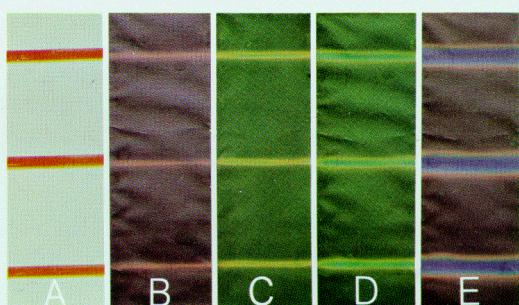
A-B-C-D-E. Representation of the colour display of a C.L.C. plate with <<lower thermal level>> at 33°C (ELC Thermo System Bayer, plate 33). The plate is applied to a spiral shaped plastic straw placed in a grooved container made of thermal insulating material. The temperature of the liquid flowing through the straw progressively increases. A) Straw *in situ*: visualized by coloured liquid. B) <<Lower thermal level>>; liquid flowing at 33°C. The straw image appears red coloured on the plate. C), D) Sequence of the plate chromatic variations with T fluctuations; C) 34°C: green colour; D) 34.5°C; the green colour persists together with the appearance of small, orange coloured, chromatic halo (lateral thermal diffusion). E) <<Upper thermal level>>; liquid flowing at 35°C: blue colour. Slightly larger chromatic halo with additional colours (green and orange) caused by lateral thermal diffusion. It can be seen that progressive distortion of simple CT. image of the straw, has occurred by a significant increase in diameter at the higher T values, due to lateral thermal diffusion.
